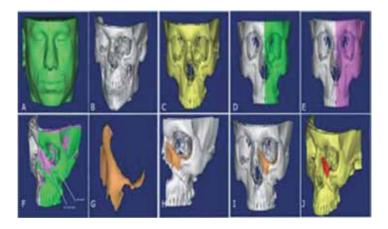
Treatment of orbital floor defect in a trauma patient using 3D printing technology. (a) 3D model designed based on CT scan images; (b) removal of soft tissue on differences between soft and hard tissue density; (c) removal of excess bone; (d) dividing the face into two halves from symmetry line; (e) mirroring the uninjured side on the other side; (f) comparison of the injured half and the mirrored half and finding their differences; (g) differentiation of the ideal design; (h) precise adaption on injured half; (i) correction of the design by removal of excess components; (j) final model.
